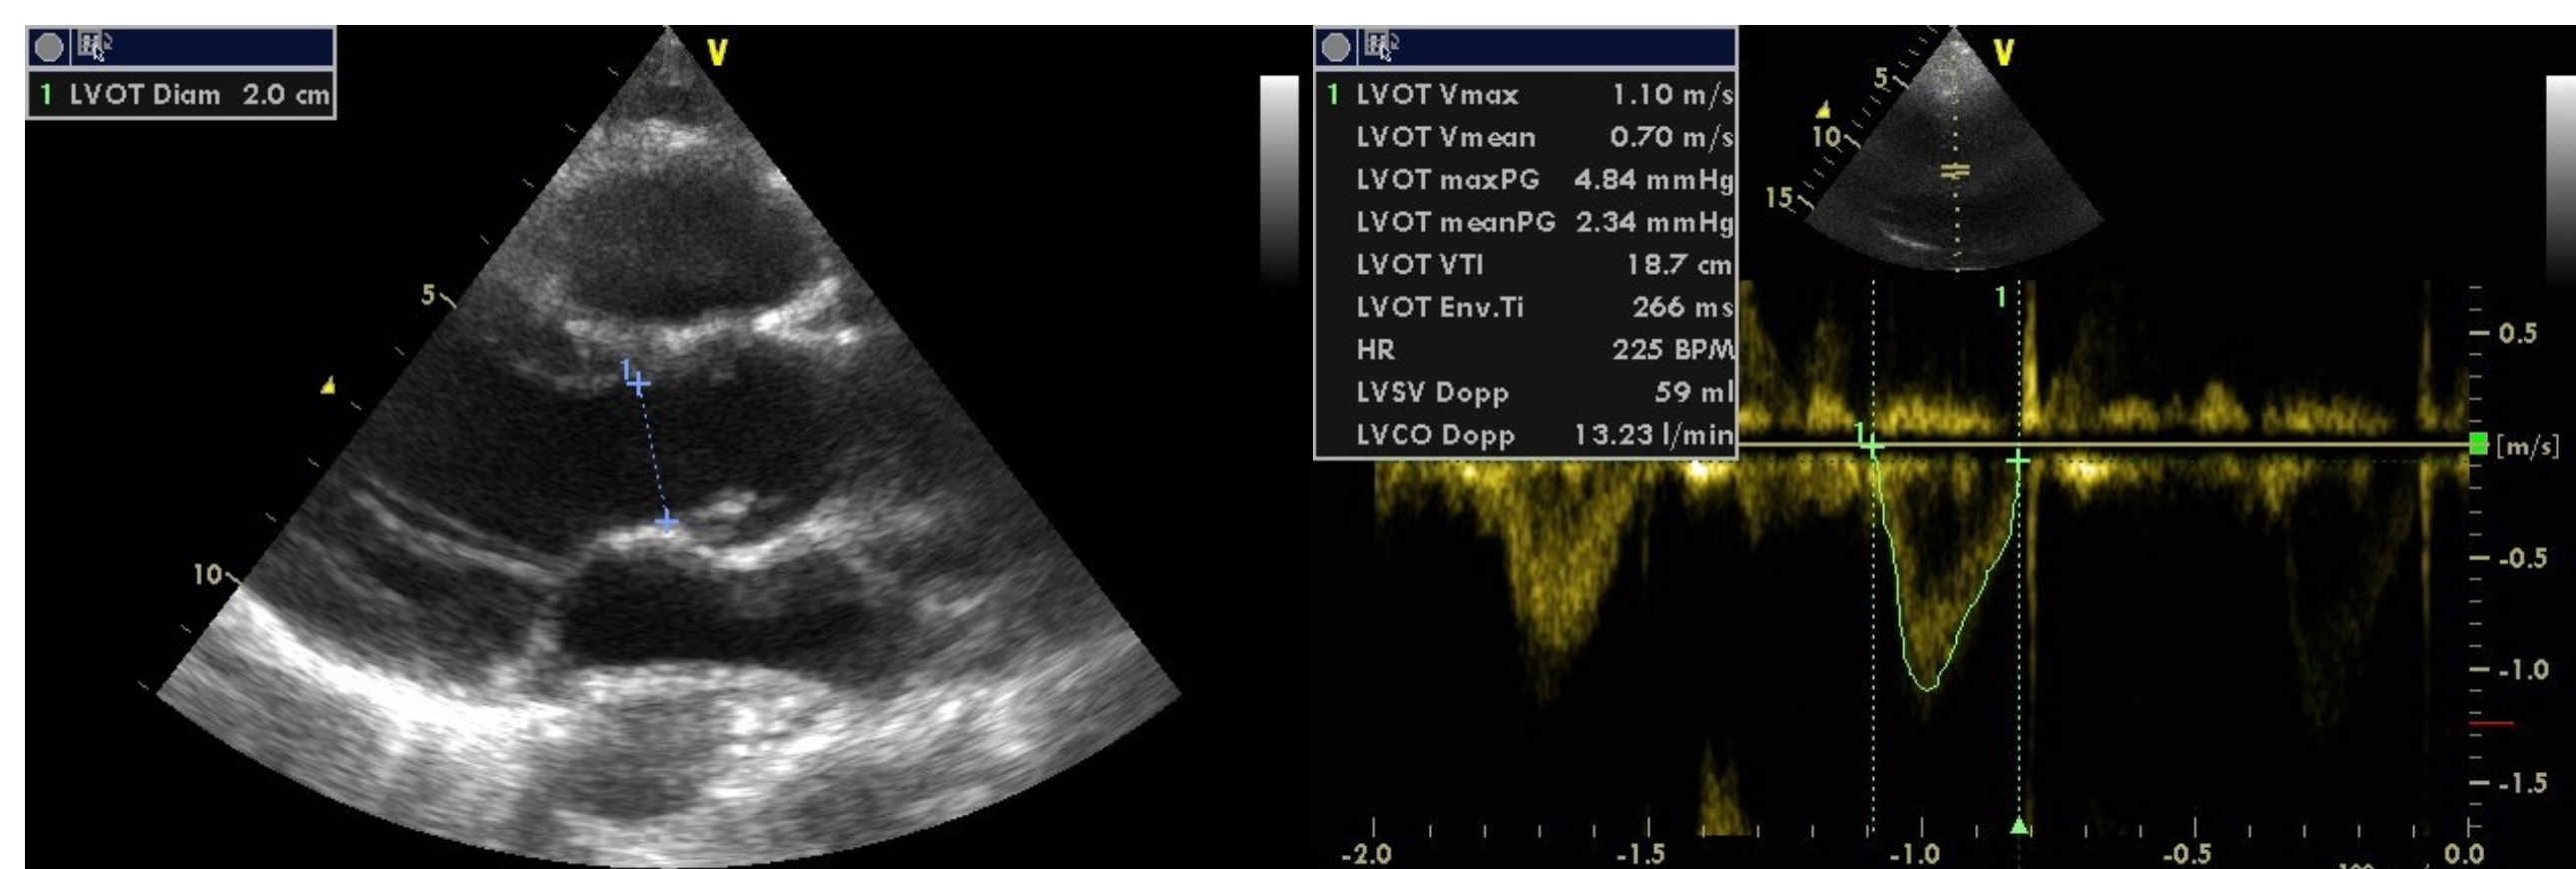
Parasternal scan of the heart. LVOT diameter is measured in centimeters during mid-systole, at the "between the hinge points of the aortic valve leaflets from inner edge-to-inner edge" [1].
